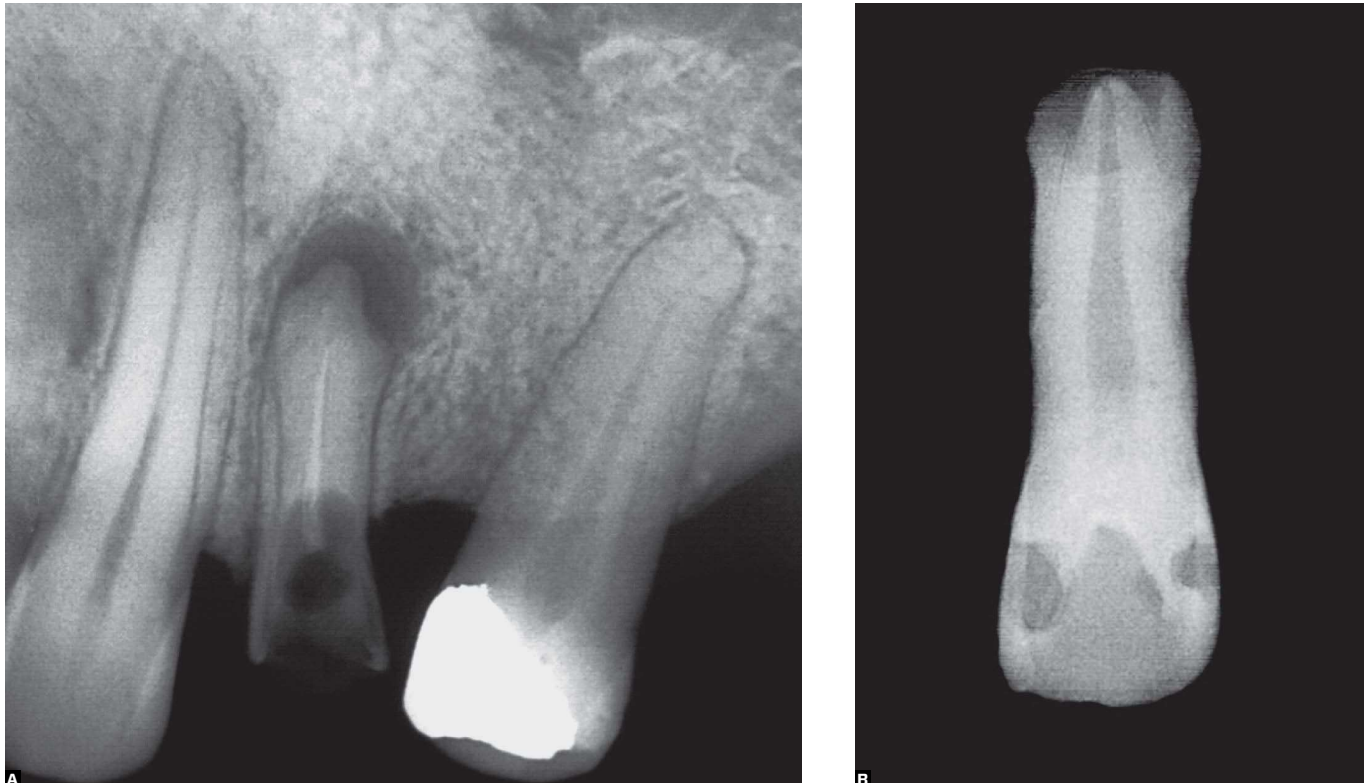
Upper premolar and incisor with hypercementosis in shape of “shirt sleeve cuff”. This aspect is provided by the presence of chronic periapical lesion and increased formation of reactive nature in the periodontal periphery of the lesion.
